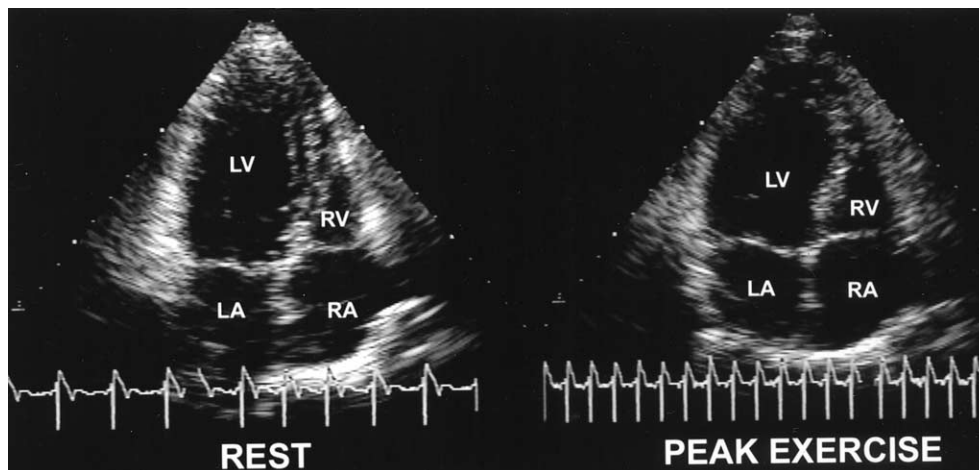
Exercise echocardiogram obtained from an apical four-chamber view of the heart in a 73-year-old woman with a hypertensive response to exercise. An end-systolic image taken immediately after peak exercise (right) shows an enlarged left ventricular (LV) cavity compared with image at rest (left). LA = left atrium; RA = right atrium; RV = right ventricle.
